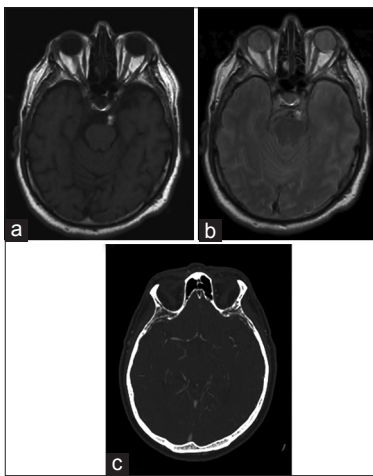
(a,b) T1 and T2 MRI sequences revealing a left-sided heterogeneously enhancing lesion adjacent to the cerebral peduncle. (c) CT angiogram revealed no evidence of aneurysm malformation
